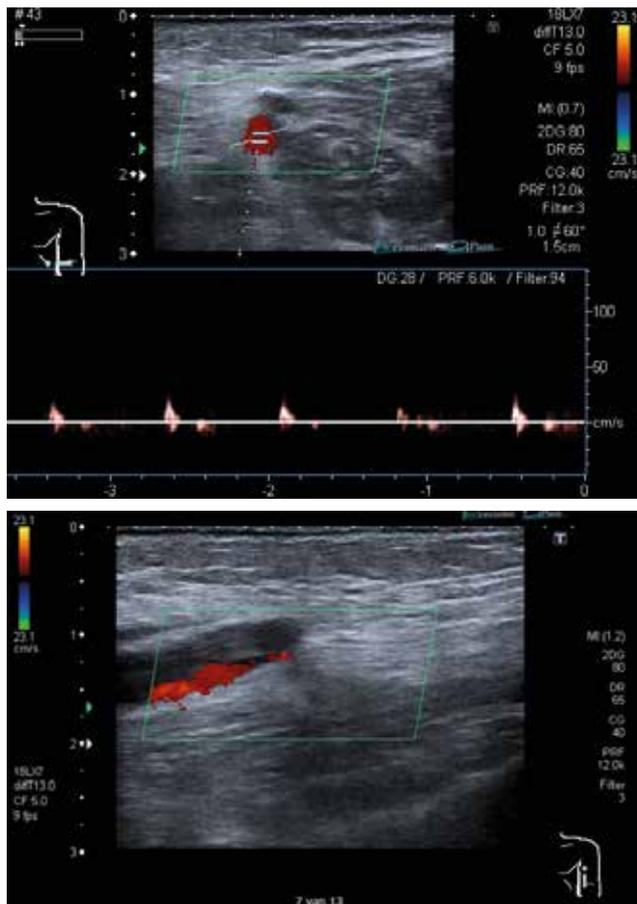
Combined Doppler and ultrasound study of flow in the distal brachial artery in the transversal (figure 1) and longitudinal plane (figure 2)
